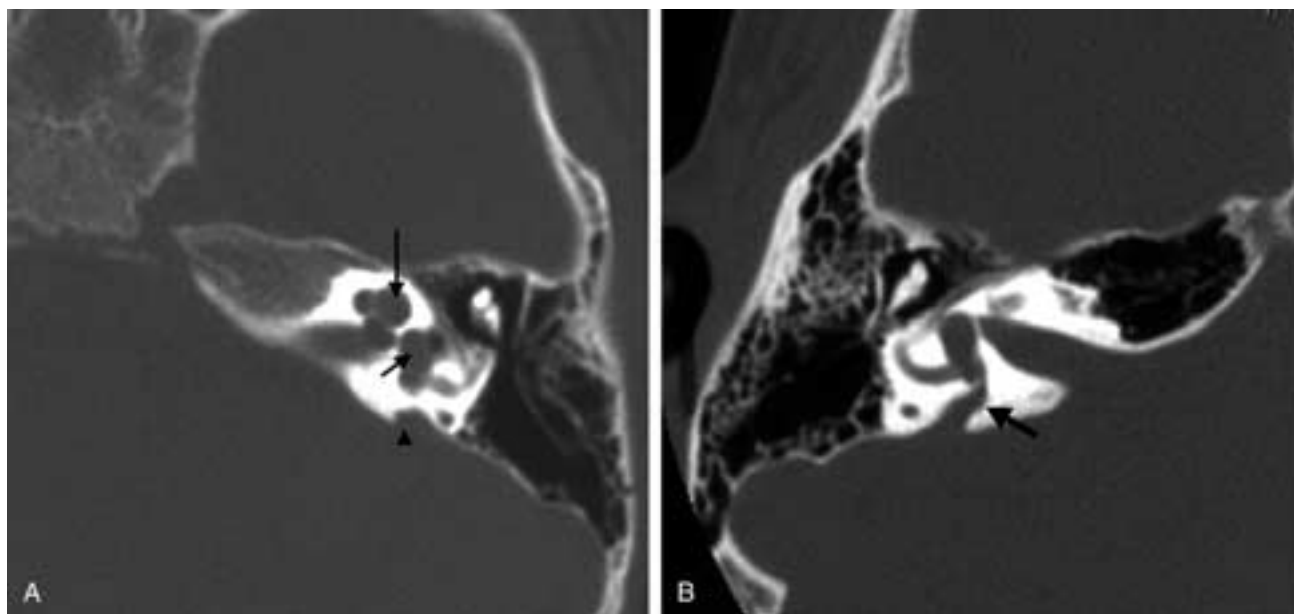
Mondini malformation. A, Axial CT image showing the sac-like representation of the second and third cochlear turns (*long arrow*), dilated vestibular aqueduct (*arrowhead*), and dilated vestibule (*short arrow*). B, Axial CT image of another patient with the Mondini malformation with an enlarged vestibular aqueduct (*black arrow*) extending to the vestibule.
